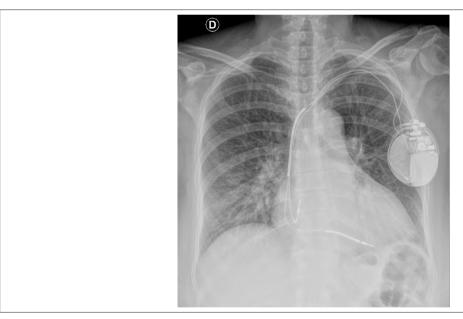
Chest X-ray (posterior-anterior view): presence of cardiac pacemaker, worse pulmonary congestion, cardiomegaly (+++).
